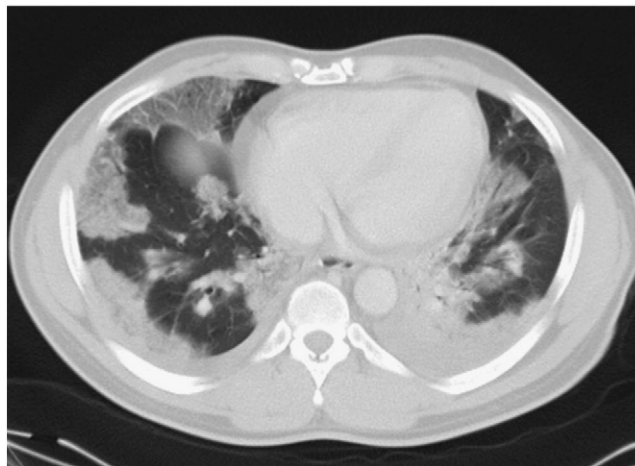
Chest CT scan revealing bilateral diffuse pulmonary airspace opacities and consolidations, suggestive of pneumonia.
